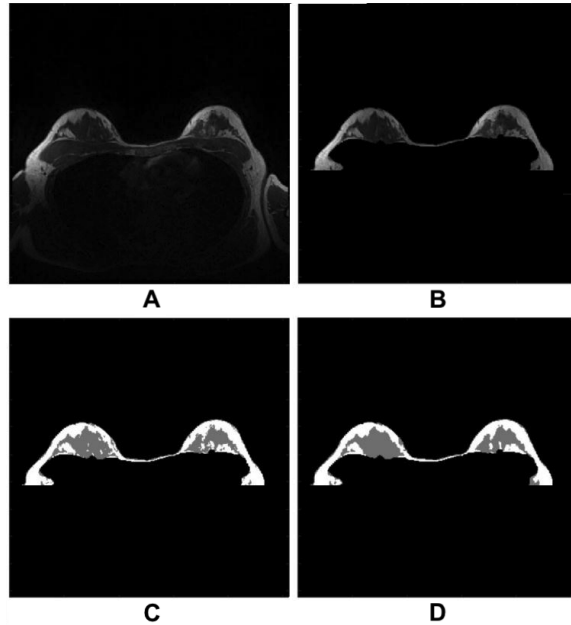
(A) Axial slice of a 3-D breast MRI volume; (B) Same slice contaminated by a bias field and Rician noise; (C) Segmentation obtained using the GMM-based method of [105]; (D) Segmentation obtained using the proposed method.
